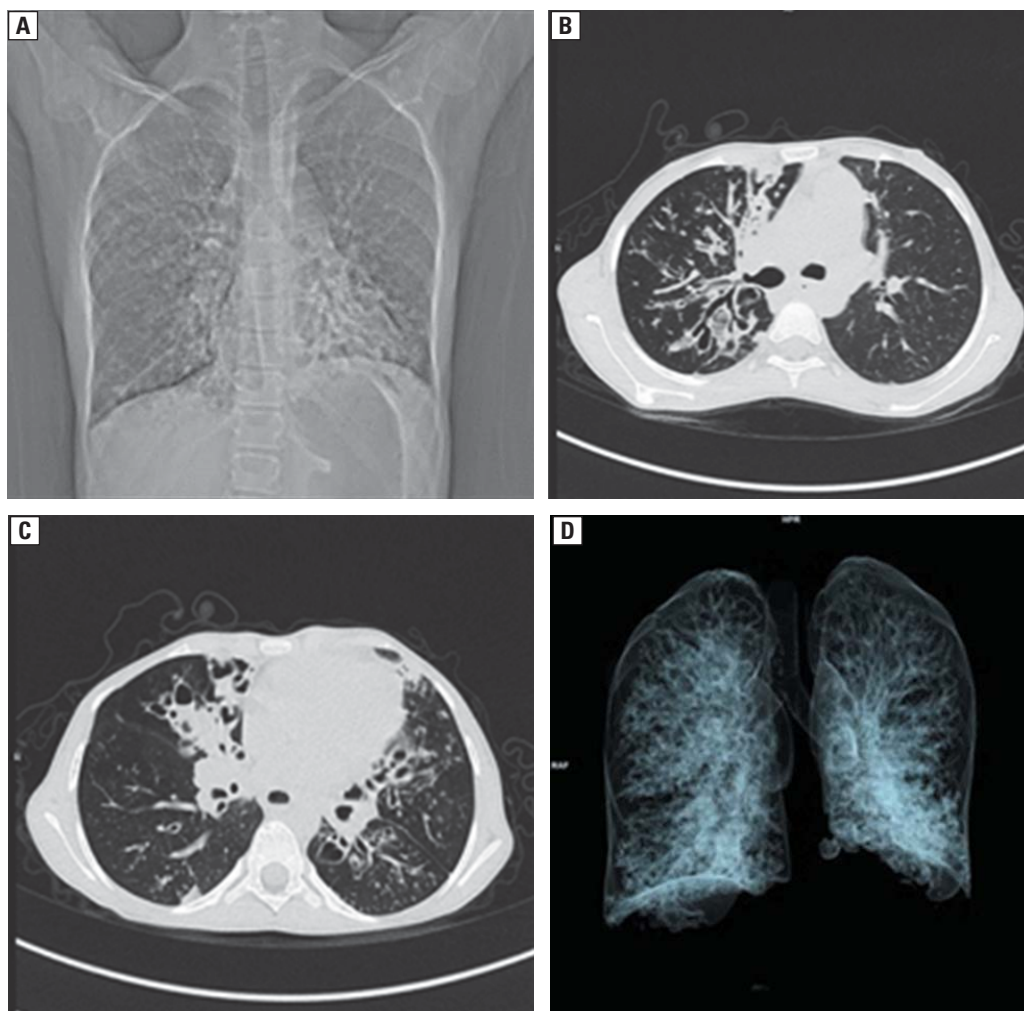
High-resolution computed tomography of the chest. A. Frontal plane; B. Cystic bronchiectasis with thickening of bronchial walls; C. Sacular dilatation of bronchi, partly with mucoid impaction in some places; D. three-dimensional imaging — a significant degree of cylindrical and cystic bronchiectasis in both lungs
